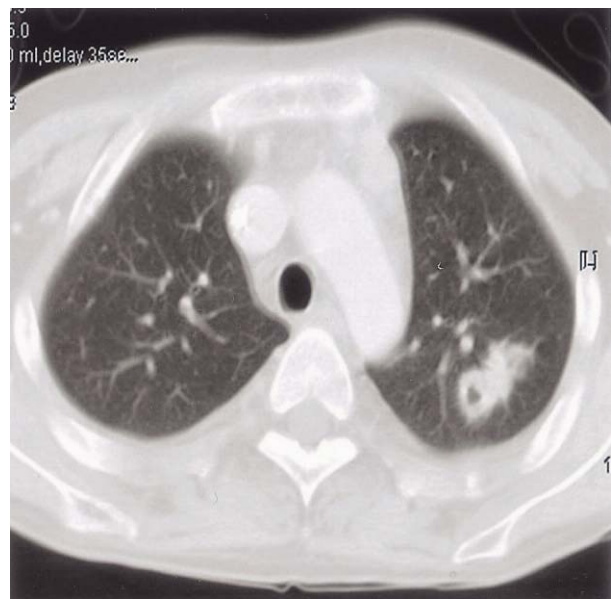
Chest CT showed a irregular, spiculated nodule with cavity at the apicoposterior segment of the left upper lobe.
